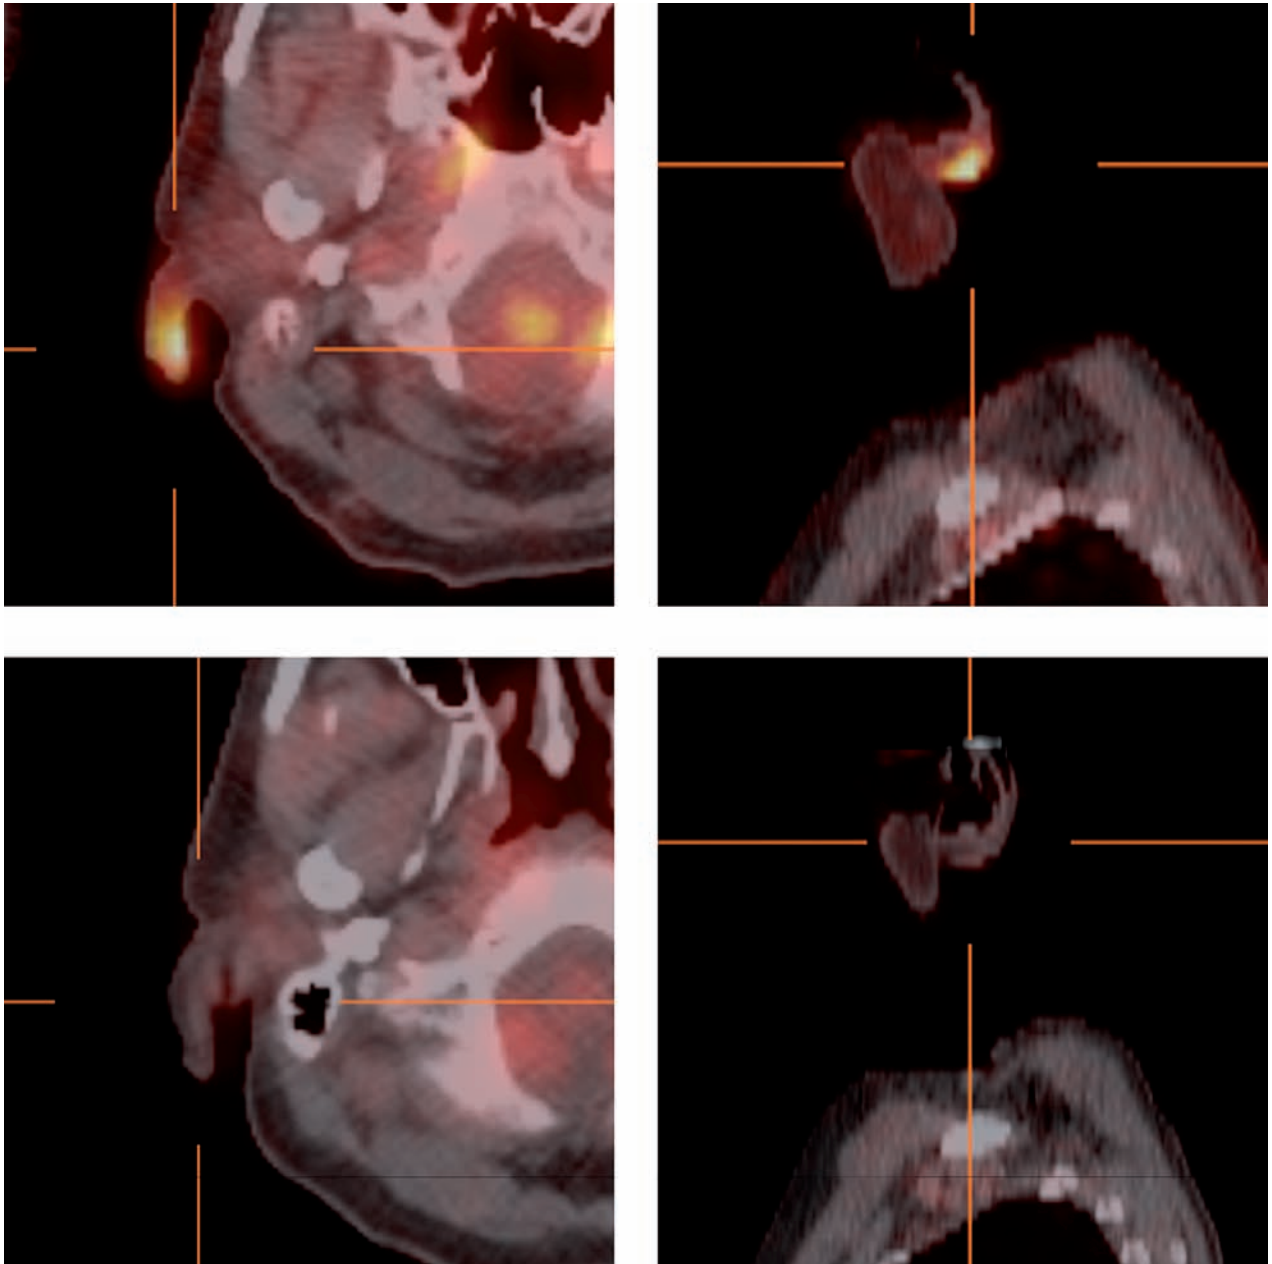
^{18}F -FDG-PET scanning with focus on right earlobe before (first row) and after (second row) treatment with 6 doses of infliximab
